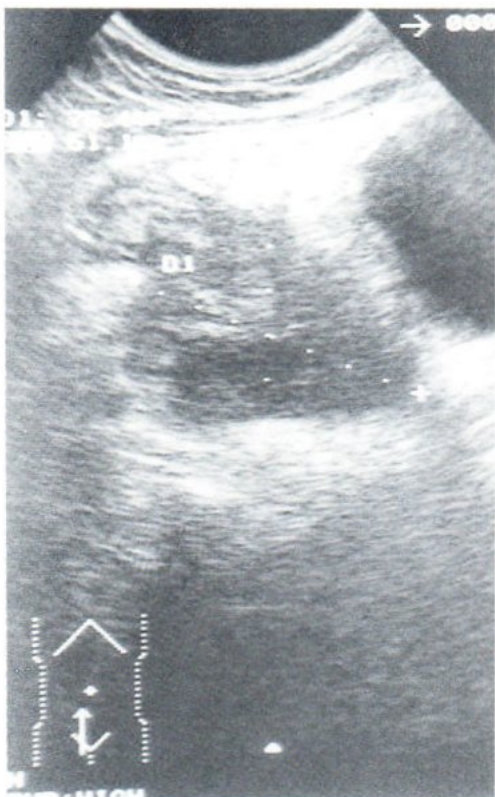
Sagittal ultrasound shows a mixed echogenicity mass at the right iliac fossa, closely related to a loop of bowel superiorly.
